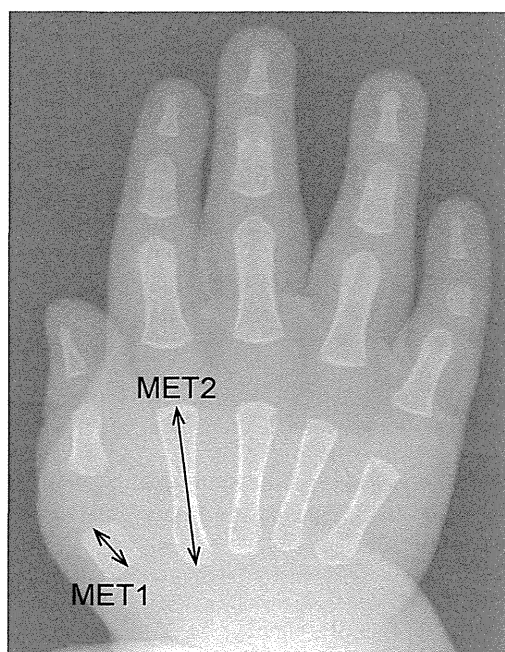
An anteroposterior radiograph of the right hand of Patient 1 at the age of eight months showing marked shortening of the first metacarpal bone. The MET2/MET1 ratio and the corresponding SD value is 2.9 and 16.3, respectively.
